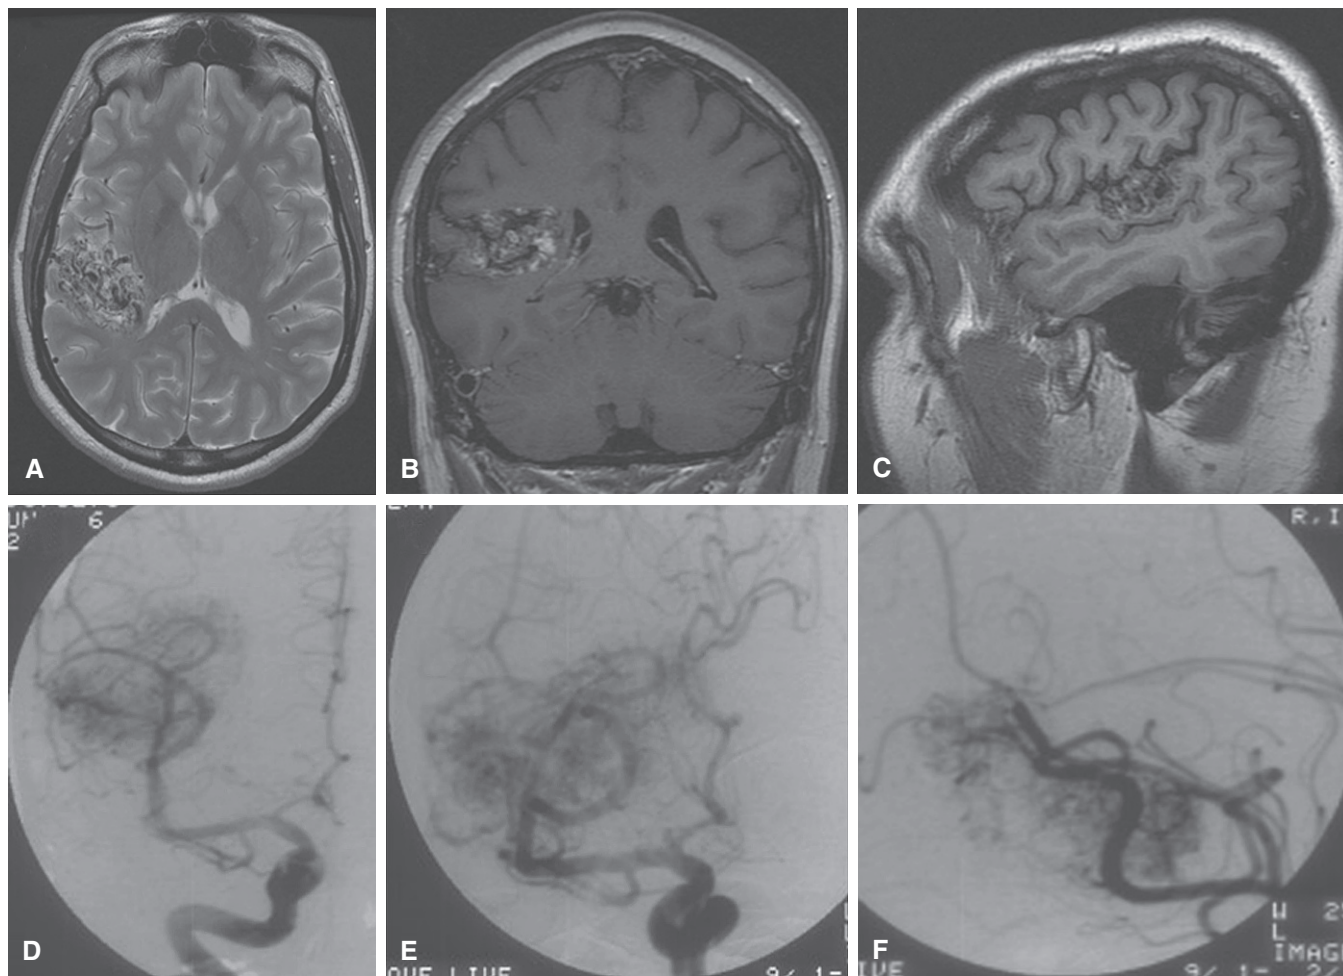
A–C, Preoperative magnetic resonance imaging (MRI) demonstrates an arteriovenous malformation (AVM) in the posterior insular and superior temporal cortex. A, T2-weighted axial MRI; B, T1-weighted coronal image with gadolinium enhancement; C, T1-weighted sagittal image. D–F, Preoperative angiography shows this Spetzler-Martin grade III AVM with feeding arteries originating from insular branches of the middle cerebral artery. Right internal carotid artery injection, anteroposterior view (D), anterior oblique view (E), and lateral view (F).
